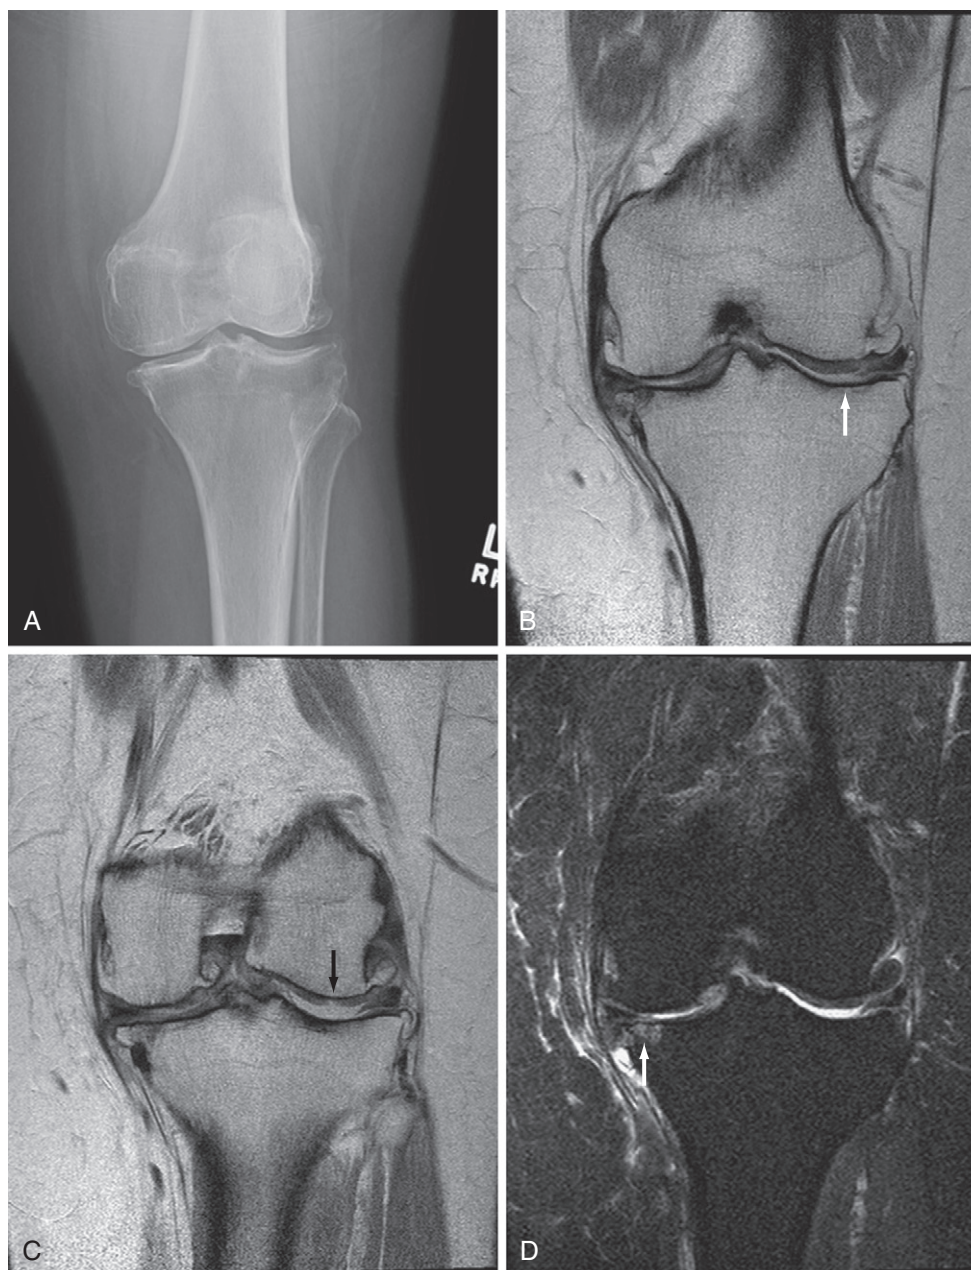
Osteoarthritis of the knee (x-ray and magnetic resonance imaging [MRI]). A, Anteroposterior x-ray view of the left knee shows large osteophyte of the medial and lateral tibiofemoral joint and mild medial joint space narrowing. B and C, Coronal proton density-weighted MRI confirms the presence of large osteophytes in the tibiofemoral joint, shows diffuse cartilage loss of the medial tibia and femur, and discloses a denuded bone with complete loss of cartilage in the lateral tibial plateau (arrow in B). A small focal cartilage defect of the lateral femoral condyle (arrow in C) is also evident. Both lateral and medial menisci are partially macerated, and a subluxation of the medial meniscus is seen, along with severe cartilage loss on the medial and lateral tibial plateau and the medial femoral condyle. D, Coronal T2-weighted fat-suppressed MRI shows medial tibial plateau subchondral bone marrow edema (arrow in D). (Courtesy Professor Ali Guermazi, Boston, Mass.)
